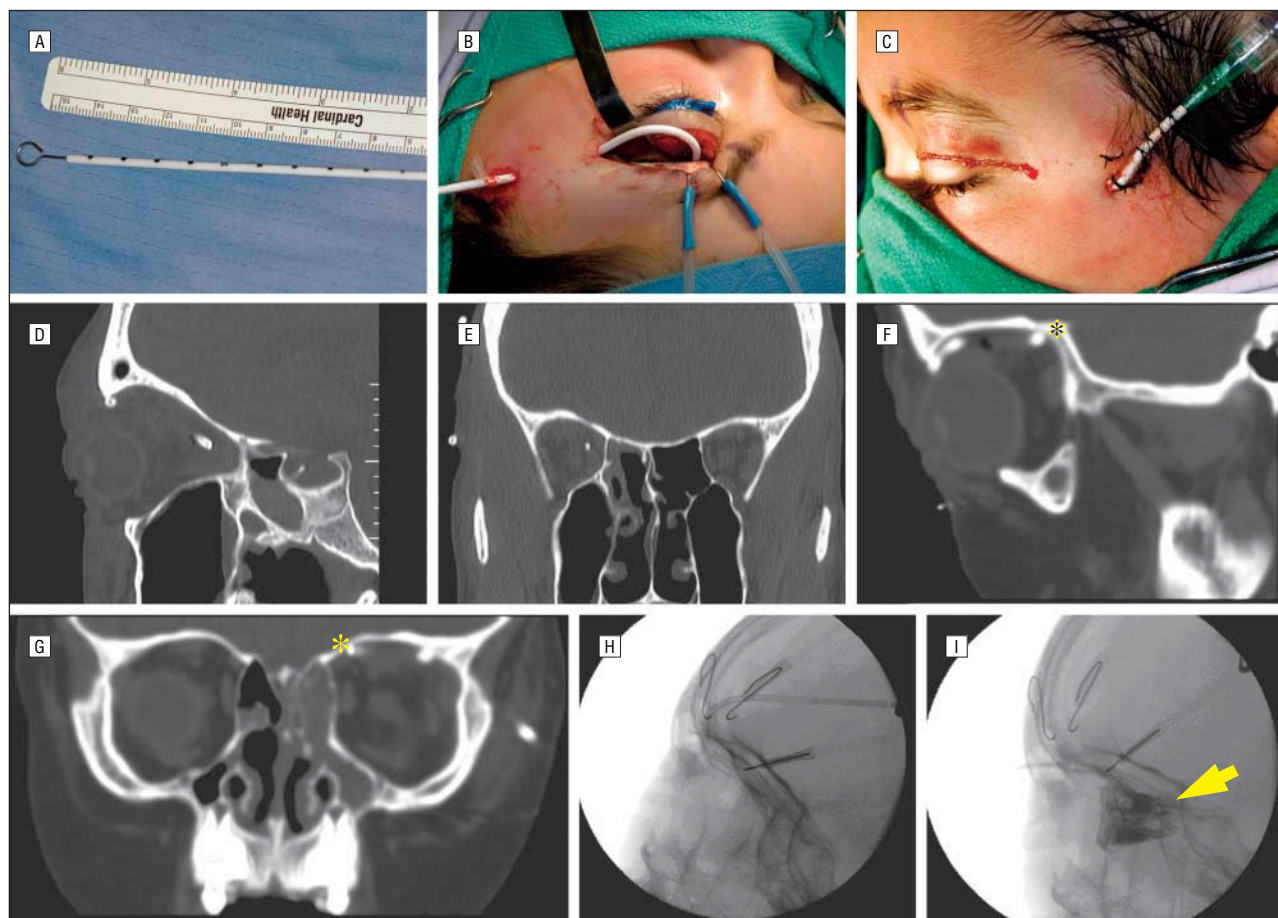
Surgical technique and results. A, Radiopaque catheter was used to facilitate visualization. Ten-millimeter marks on the catheter can be used to aid in localization. The Innervision Ventricular Catheter (Medtronic, Inc, Minneapolis, Minnesota) is 15 cm long and made of translucent silicone elastomer containing a barium-impregnated stripe. B, Placement of the intraorbital catheter and externalization through a lateral stab incision. C, Catheter placement after closure. Sagittal (D) and coronal (E) computed tomographic scans of patient 1 revealing excellent position of the radiopaque catheter tip. Sagittal (F) and coronal (G) computed tomographic scans of patient 2 showing the catheter (asterisk) curving inside the orbit and pointing away from the orbital apex. H and I, Intraoperative fluoroscopy allows for localization of the catheter tip. H, Sagittal view before the infusion of iohexol. I, Immediately after iohexol infusion. The infusate (arrow) can reveal the direction of fluid spread.
